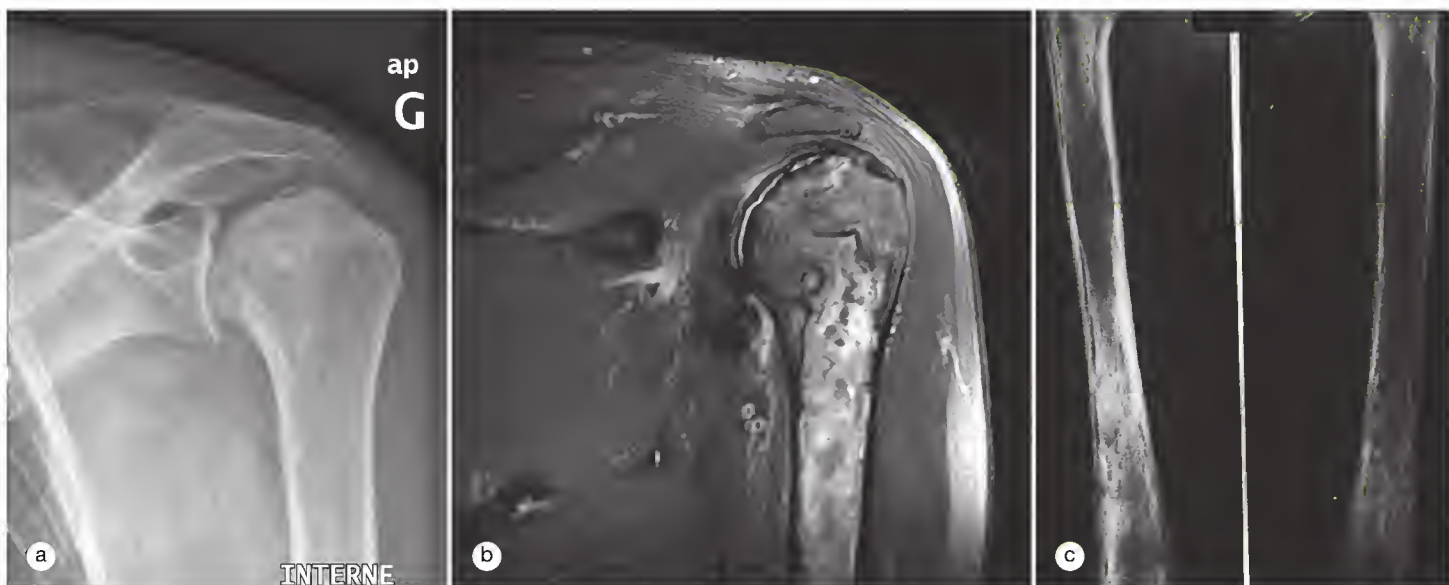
Typical features of ischemic bone complications in Gaucher disease. A standard radiograph (a) and T2-weighted magnetic resonance image (b) of the proximal end of the humerus show osteonecrosis of the left humeral head. (c) Radiograph of the right humeral diaphysis of a second patient shows bony infarction with heterogeneous condensation of the diaphyseal bone and a cortical reaction producing cortical splitting, the so-called bone-within-bone appearance.
